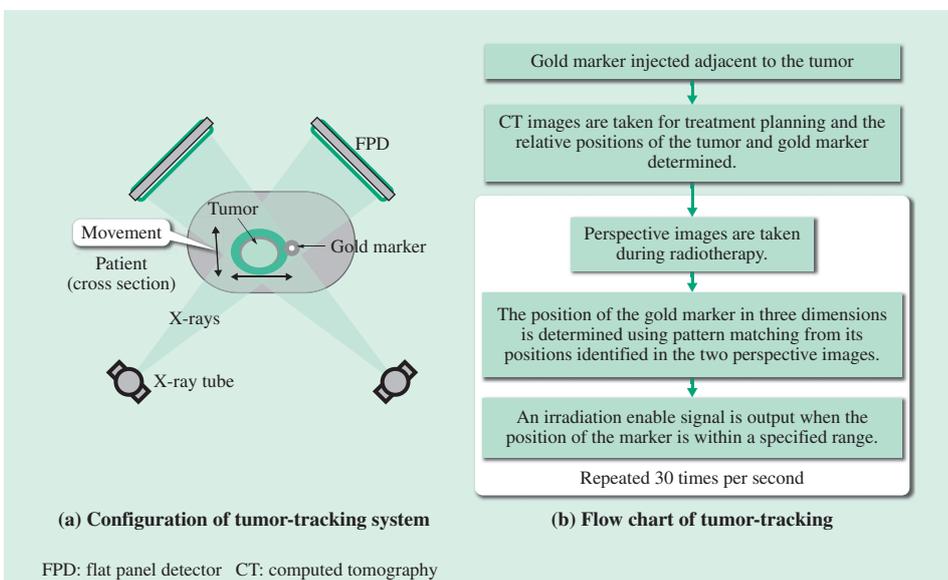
Tumor-tracking. (a) The system incorporates an X-ray imaging system that can obtain images of the patient from two different directions. (b) A gold marker injected adjacent to the tumor is captured in the X-ray images and its position is determined in three dimensions using geometry based on its location above the detector (FPD). Because the position of the gold marker can be determined with high accuracy (within ±1 mm), it is possible to track the movement of the organ.
